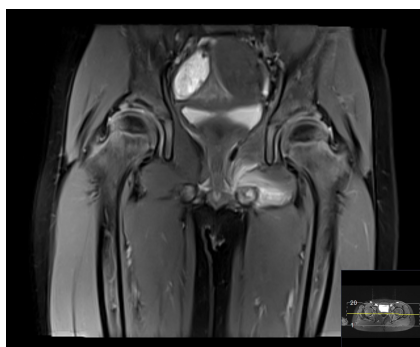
Initial MRI. DP-FS sequence, on the coronal plane.
